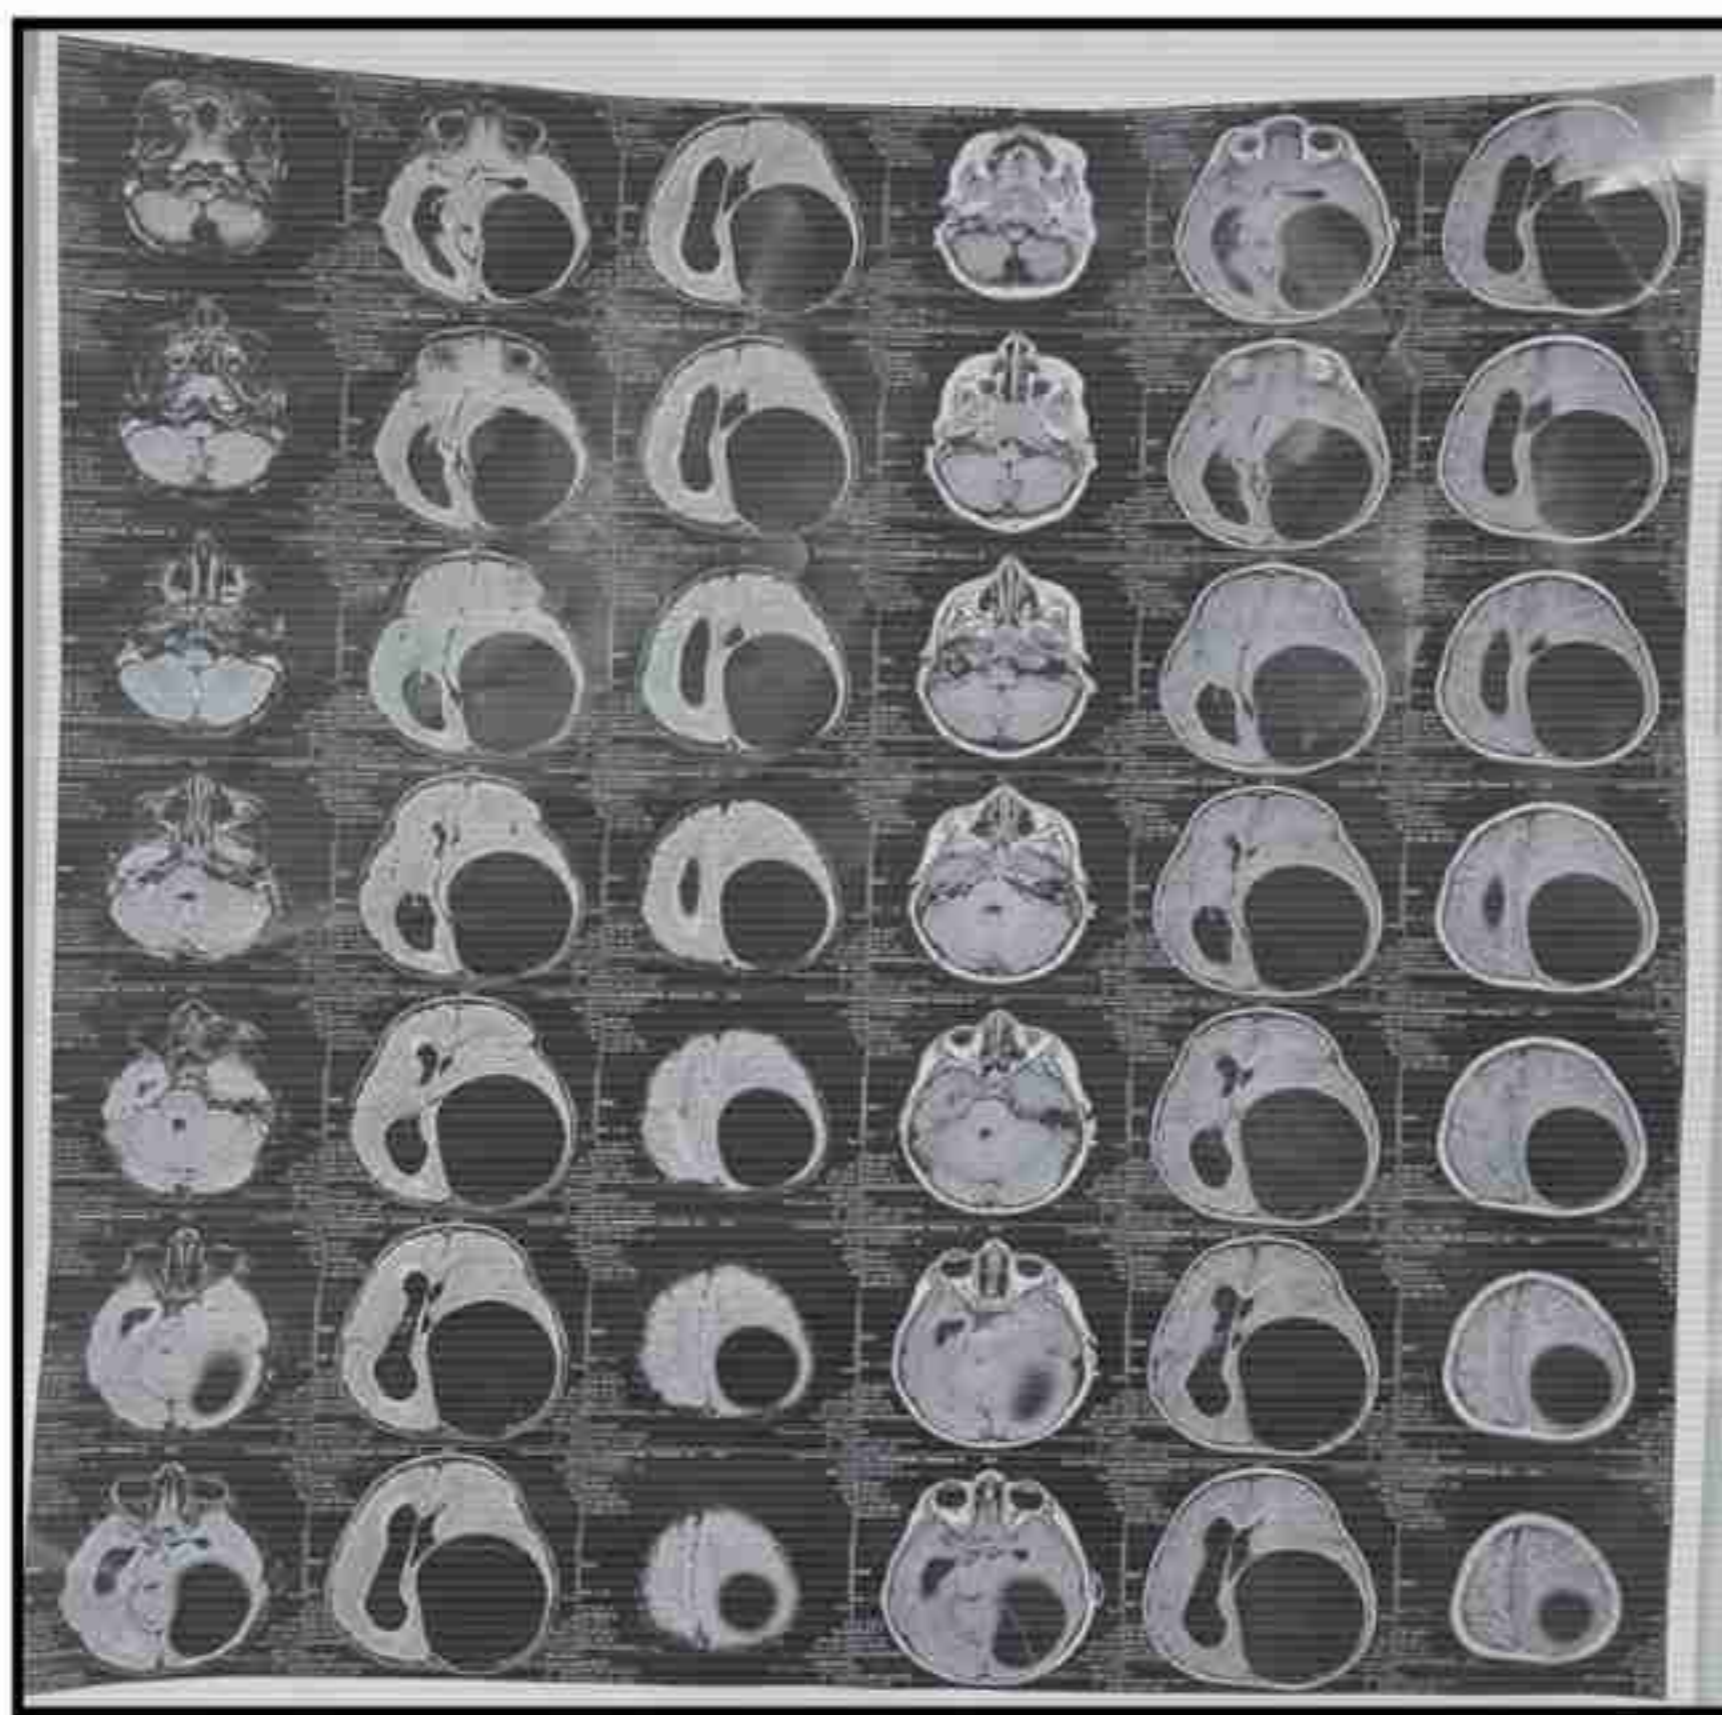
Axial T1-weighted brain MRI demonstrating a well-defined hypointense lesion in the left temporoparietooccipital lobe with significant mass effect and midline shift.
